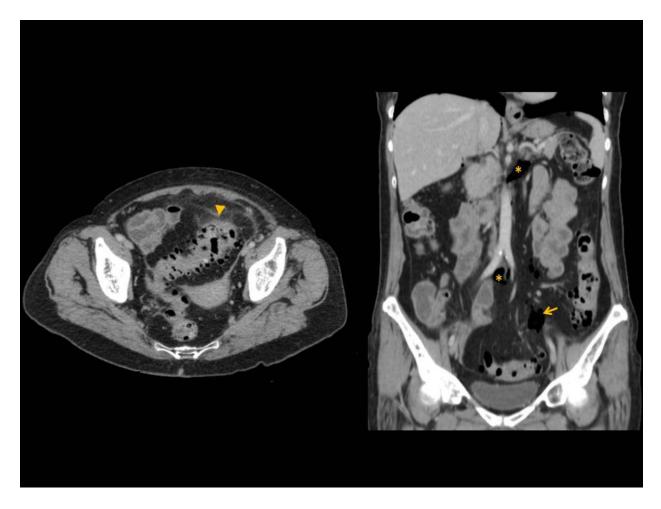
Axial and coronal CT images shows perforated sigmoid diverticulitis, with free intraperitoneal gas tracking along the sigmoid mesentery (arrows) and then the rest of the peritoneal cavity (*). The presence of mesenteric stranding (arrowhead) adjacent to the sigmoid diverticula points to the rupture local.
